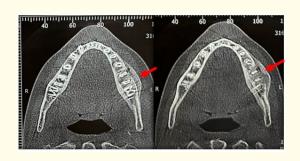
Cone Beam (axial section) showing the presence of a periosteal reaction composed of 2 layers 4mm thick, extending from 34 to 37.
